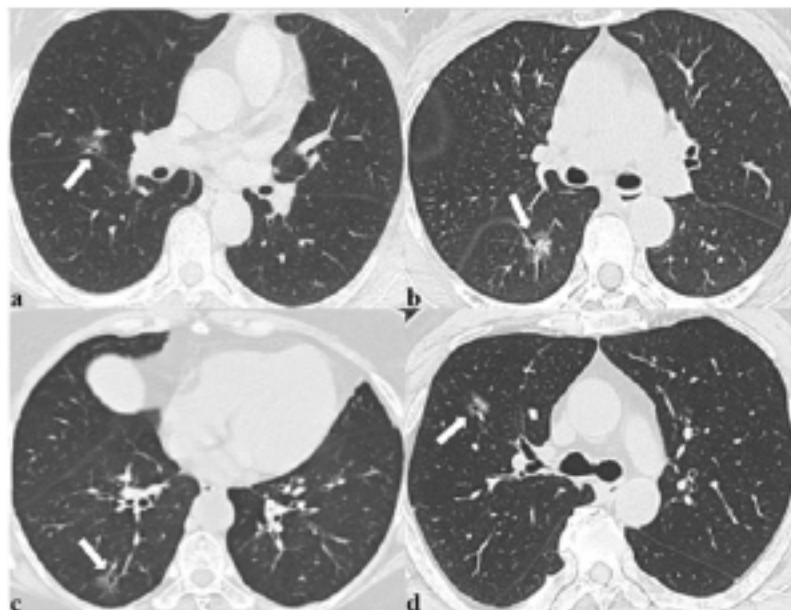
Axial CT images(a-d) showed solitary, smaller than 5mm and eccentric distributed air containing spaces in subsolid nodules with EGFR mutations.
